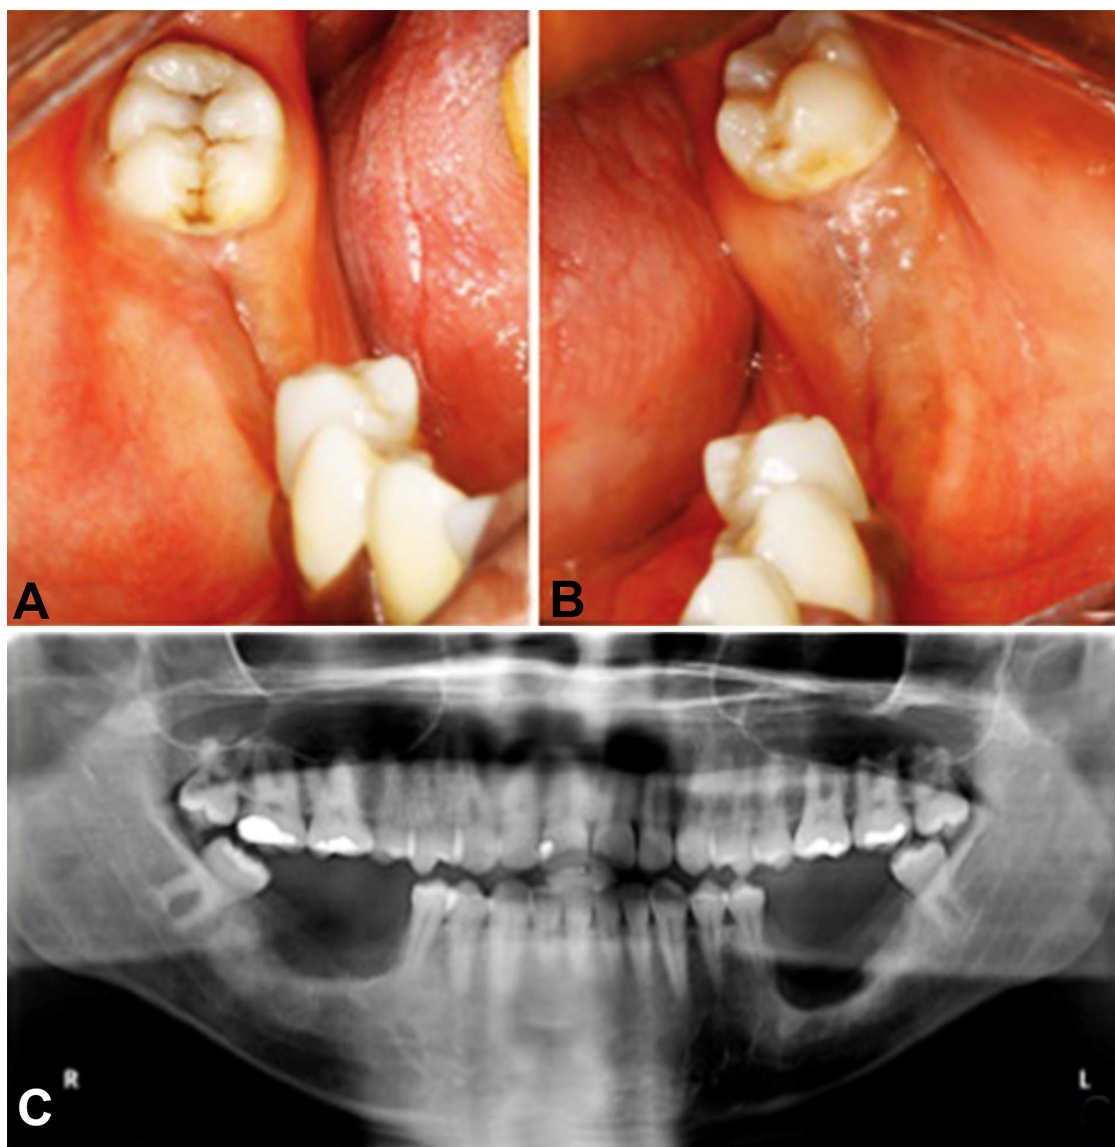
A-C – Clinical and radiographic control 3 months after the surgeries.
